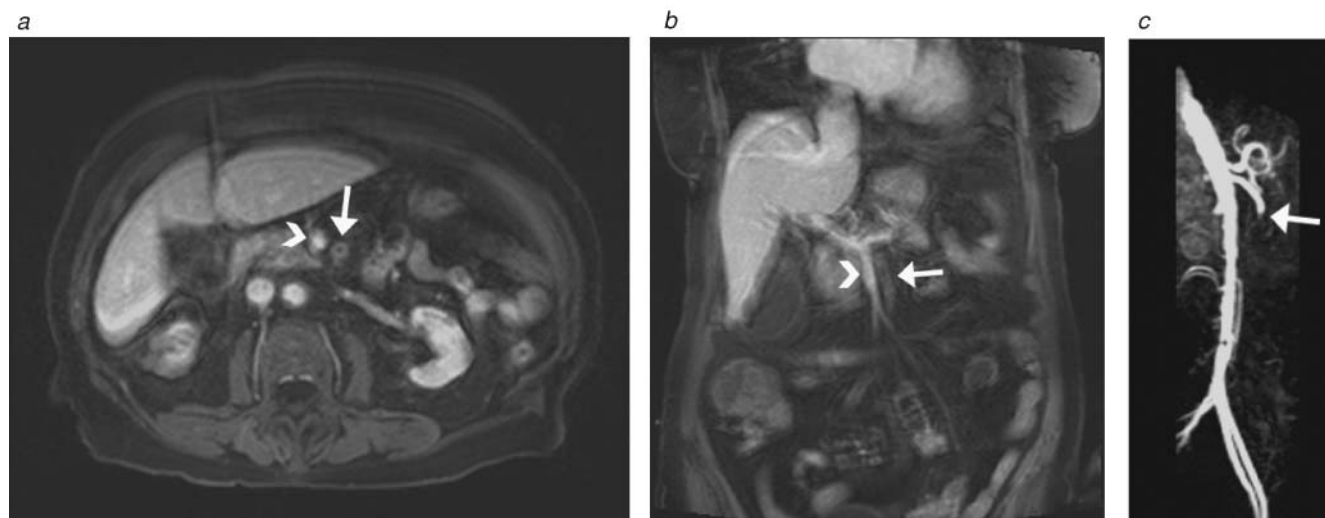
A 69-year-old male presented with acute onset of diffuse abdominal pain. Axial (a) and coronal (b) postcontrast fat saturation T₁-weighted magnetic resonance images through the upper abdomen demonstrate a filling defect within the superior mesenteric artery (SMA) (arrows) with contrast enhancement of the adjacent superior mesenteric vein (arrowheads). (c) Sagittal maximum-intensity projection from a high-resolution contrast-enhanced magnetic resonance angiogram demonstrates an abrupt cutoff of the SMA (arrow) consistent with an embolus or in situ thrombus. This was successfully treated with surgical embolectomy.
